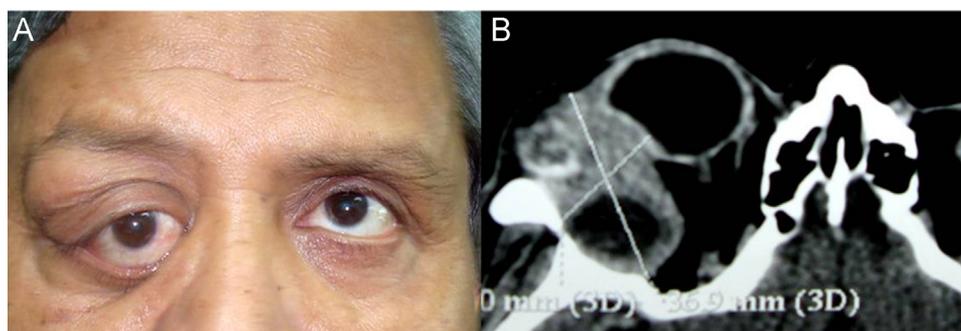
(A) Clinical photograph shows mass in the right lacrimal gland region associated with inferomedial globe dystopia. (B) Computed tomography scan (axial section) shows right lacrimal gland mass with anterior solid component with calcification and posterior large cyst.
